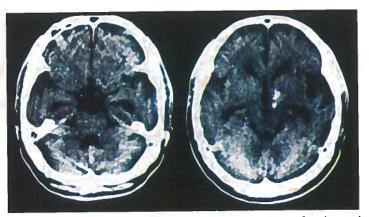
(a) CT Scan: Showing a brain tuberculoma in right thalamus
